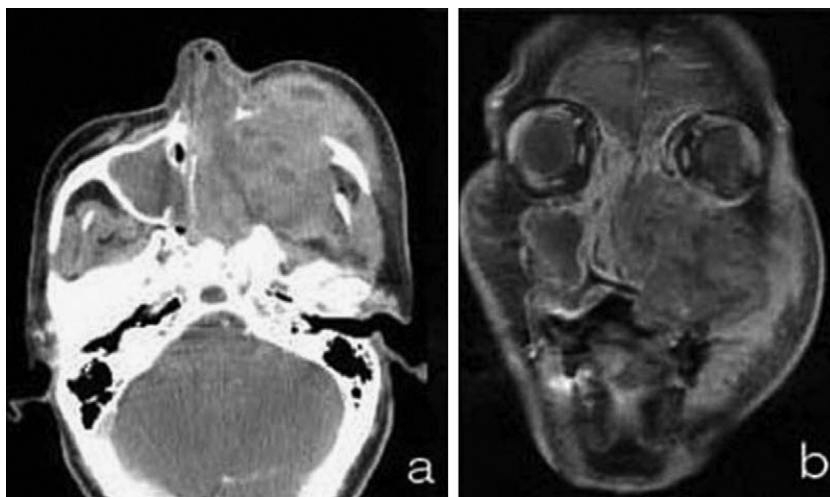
(a) CT and (b) MRI showed that the tumor had destroyed some of the maxilla, right ethmoid sinus, sphenoid sinus, and that it extended into the right nasal cavity, the orbit, pterygoid muscle, and the skullbase involved.
